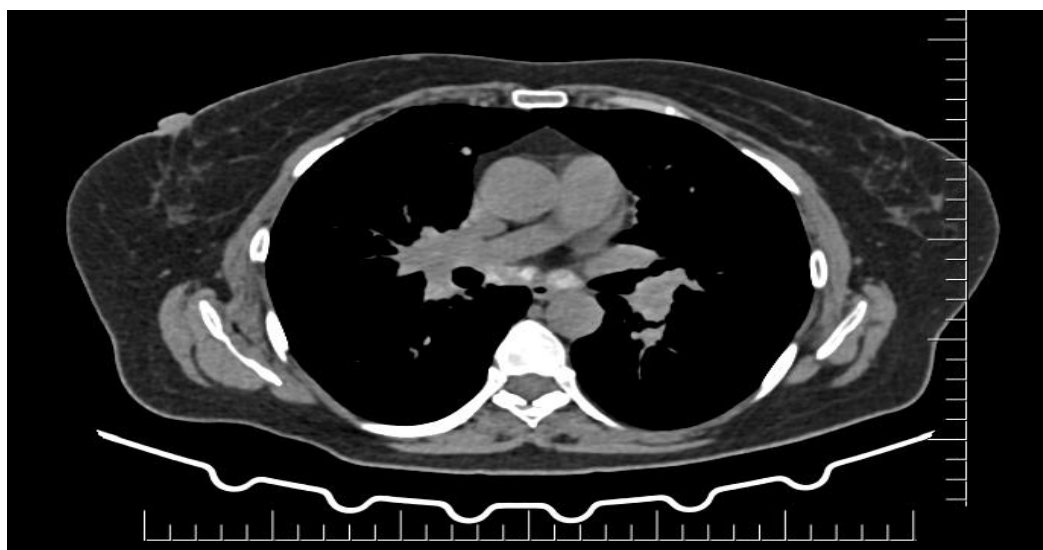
CT scan chest plain images showing calcified nodes in the subcarinal region
